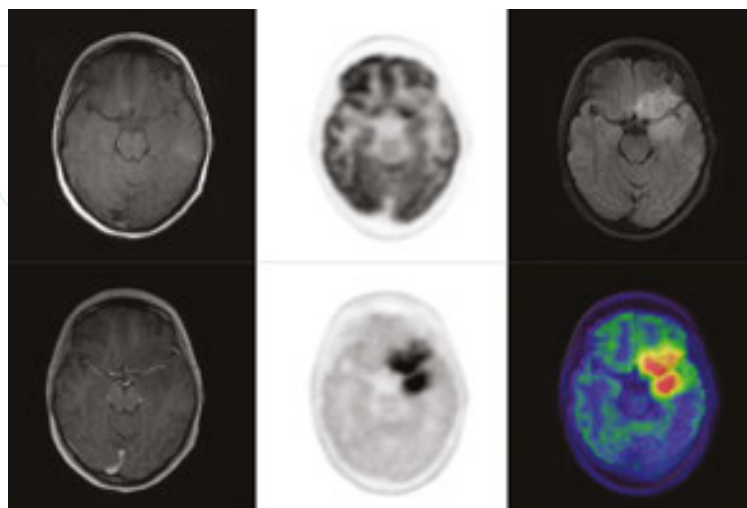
F-18 FDG PET/CT (*top row*) and F-18 FDOPA PET/CT (*bottom row*) of a left frontotemporal low-grade non-enhancing cerebral glioma showing the high tumour-to-background contrast of amino acid imaging compared with metabolic imaging.
